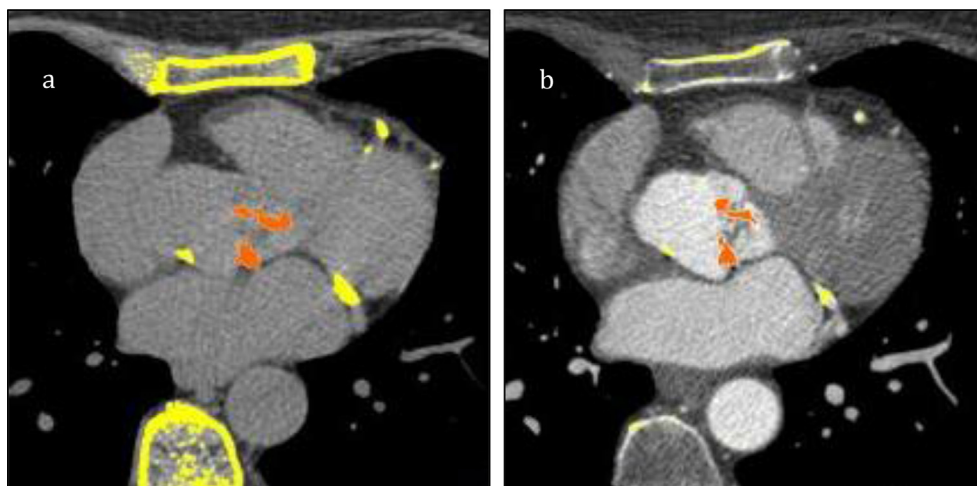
Aortic Valve Calcification (orange) using (a) Non-Enhanced Cardiac CT, and on (b) Contrast Enhanced CT (using a threshold of 614 (= mean ascending aorta + 2SD)) Hounsfield units.
